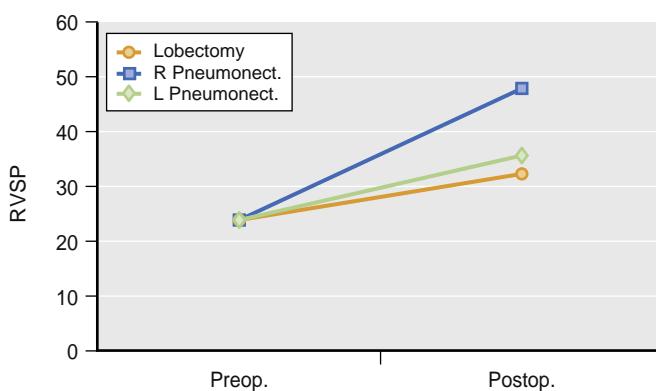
Comparison of right ventricular systolic pressure (RVSP) measured by echocardiography in patients before (Preop.) and at 6 months after (Postop.) pulmonary resections. *L Pneumonect.*, Left pneumonectomy; *R Pneumonect.*, right pneumonectomy. Note the elevated RVSP, and therefore pulmonary artery pressure, after a right pneumonectomy. (Based on data from Foroulis C, et al. *Eur J Cardiothorac Surg*. 2004;26:508.)
